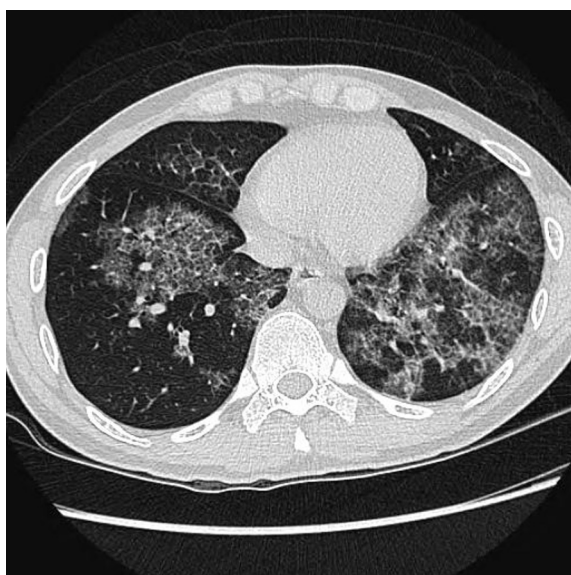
Computed tomography showing bilateral ground-glass and crazy-paving patterns.
